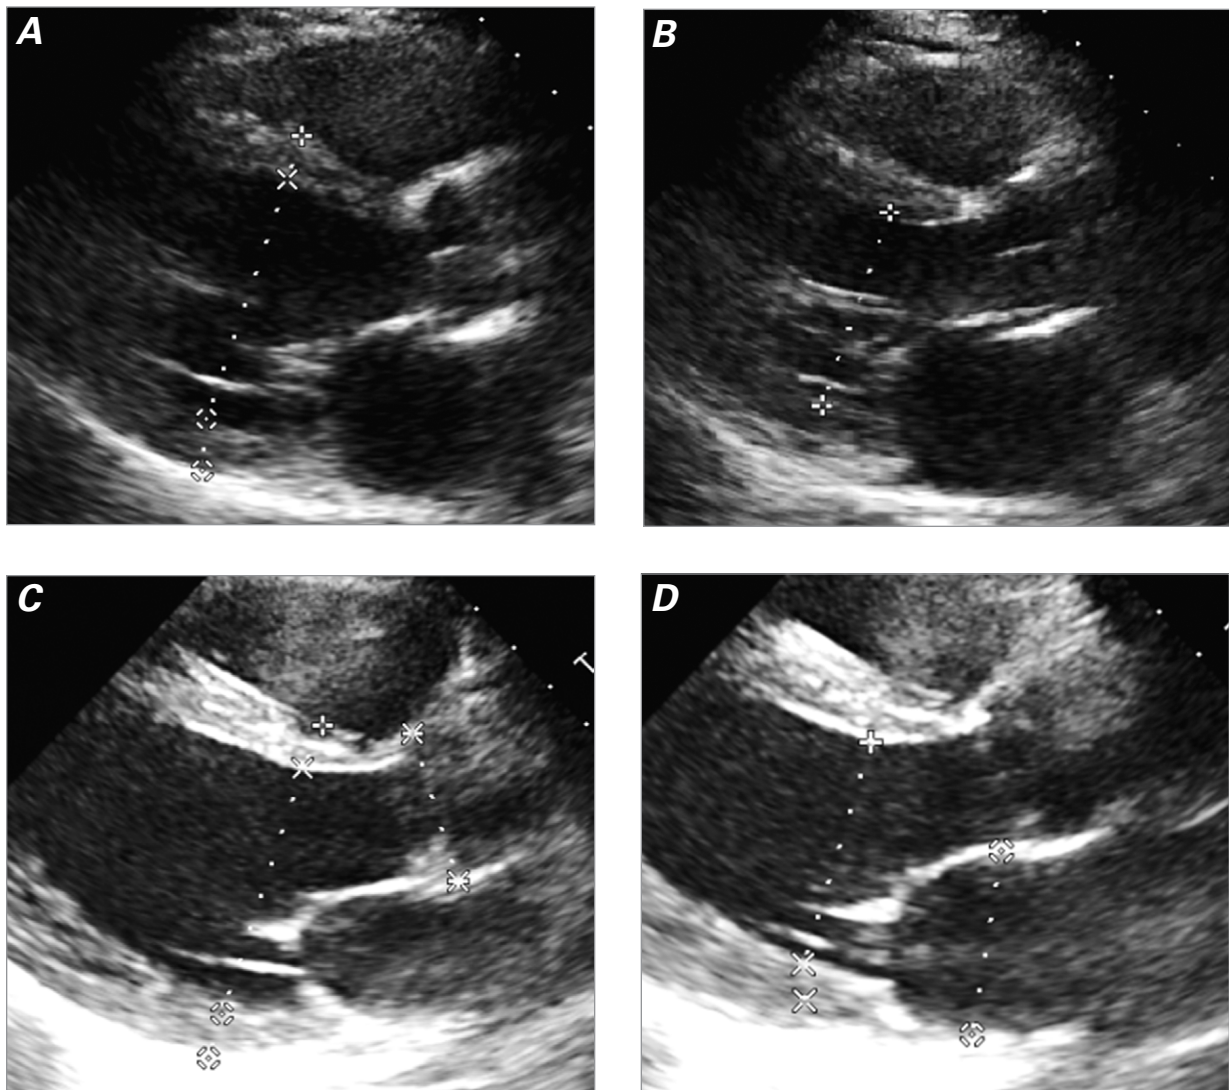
Upon the patient's hospital admission, echocardiograms (parasternal long-axis views) show a left ventricular ejection fraction of 0.18 during A) diastole and B) systole. After 2 weeks, similar views show improvement in left ventricular ejection fraction to 0.33 during C) diastole and D) systole.
